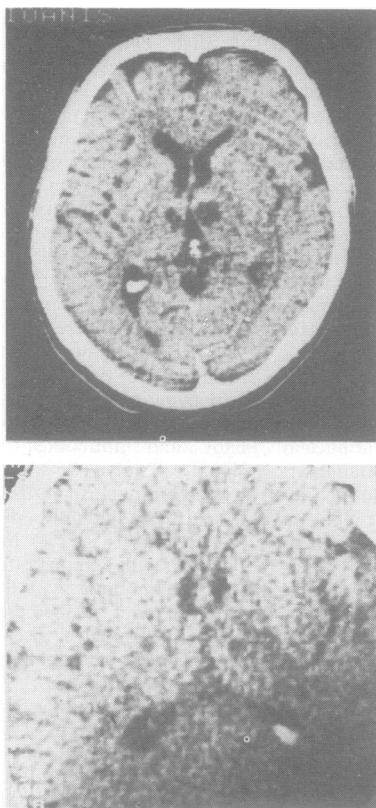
Fig (a) Brain CT scan showing hypodense areas in both thalamic areas. (b) CT scan 3 months later showing smaller hypodense areas.
